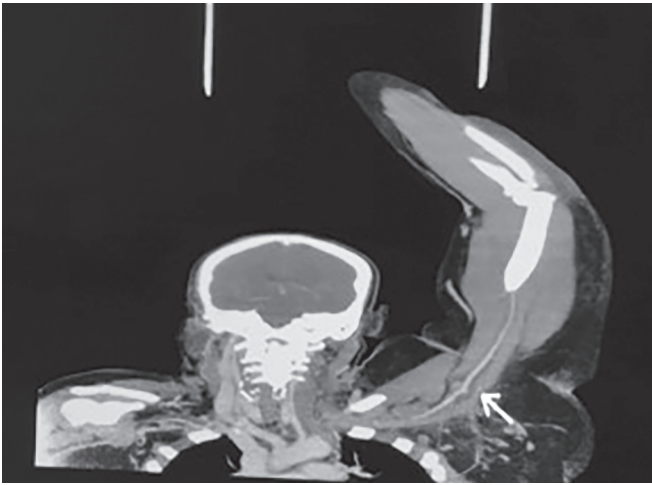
A CT venogram confirmed extensive thrombus formation from the left brachiocephalic to brachial vein
